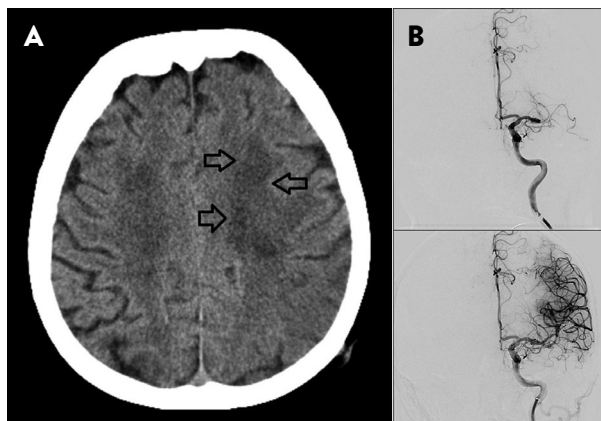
(A) Computed tomography scan showing acute ischemic stroke; (B) angiography with occlusion of the left anterior cerebral artery and finding after mechanical thrombectomy.
